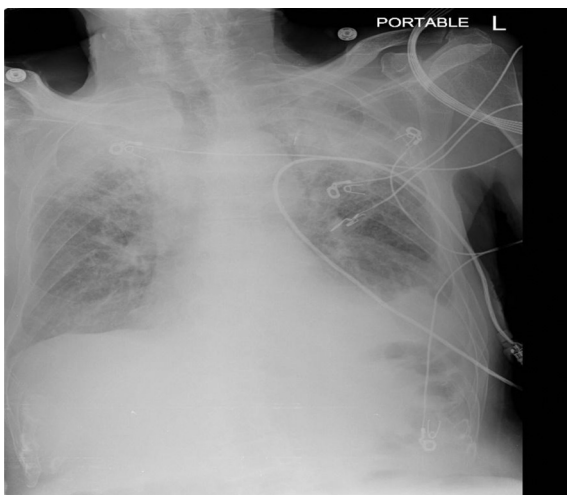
Admission Chest Radiograph demonstrated small bilateral effusions and bilateral upper lobe lung infiltrates.
